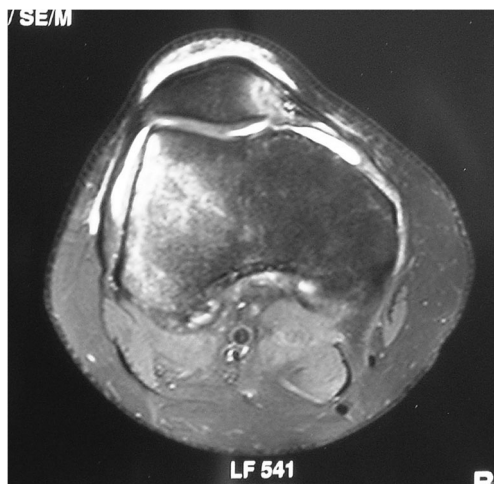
Oedema of the medial border of the patella and of the lateral condyle which is specific of acute patellar instability (MRI axial view)
